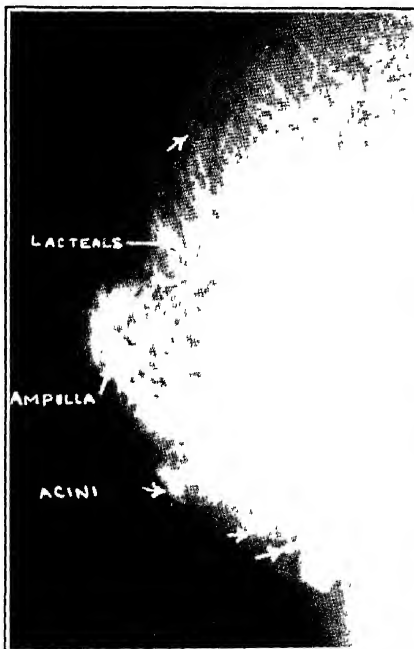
Lactating breast. Manumogram on third postpartum day shows hypertrophied ducts, dilated ampullae, and fuzzy caps (acini) on the ends of the terminal lacteals (Am J Roentgenol, March, 1938)
